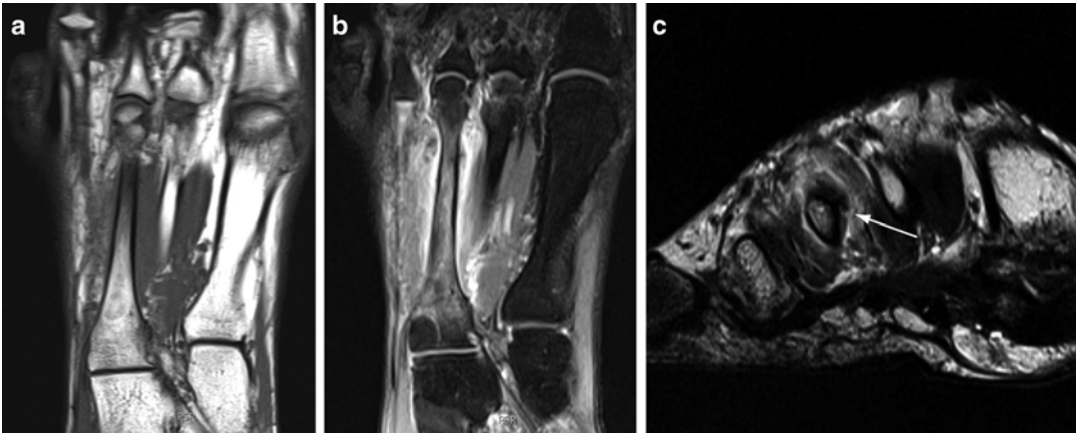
MR features of developing stress fracture. (a) Axial T1-weighted MR image shows low-signal intensity bone marrow in the third metatarsal bone from edema. (b) Corresponding T2-weighted image shows adjacent
